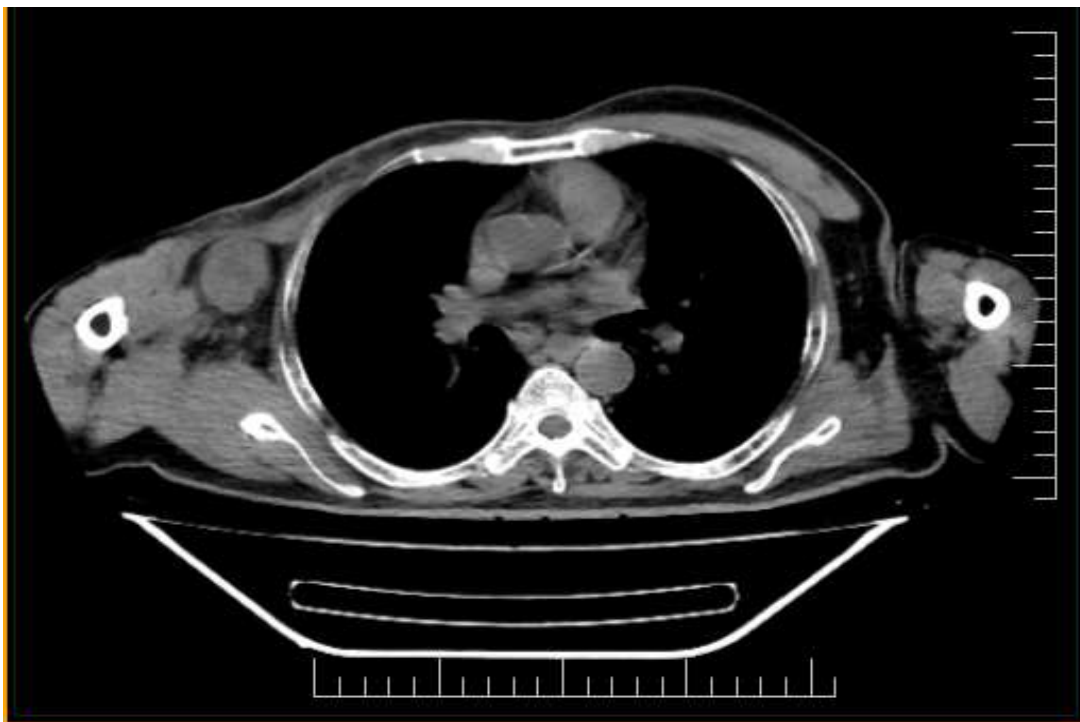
CT image showing right axillary nodal lesion
